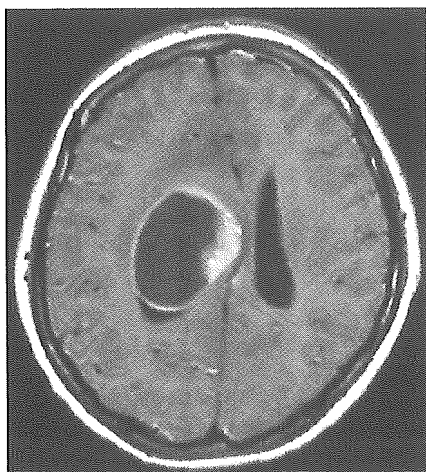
Case 1: Axial T1-weighted MR image with gadolinium-diethylenetriaminepenta-acetic acid on admission demonstrating a cystic mass with ring enhancement in the right lateral ventricle
